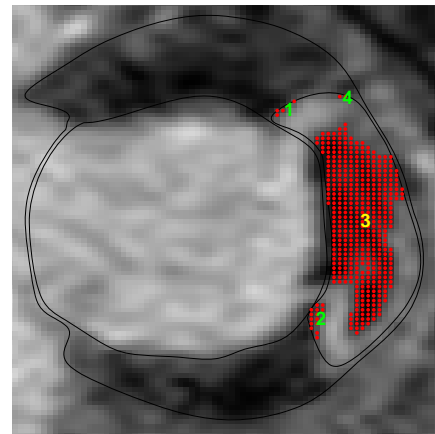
Original infarcted MRI with myocardium and scar manually delineated. Candidate MO-regions (red) detected as true (yellow numbers) or false (green numbers).
